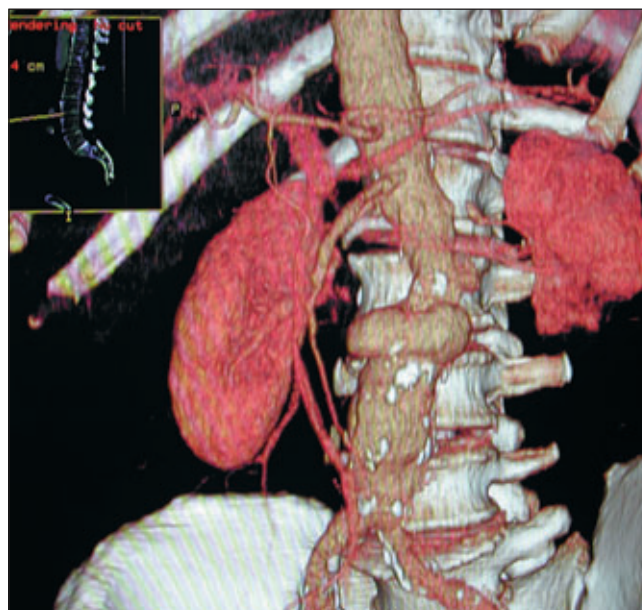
CT scan of abdominal aortic aneurysm
